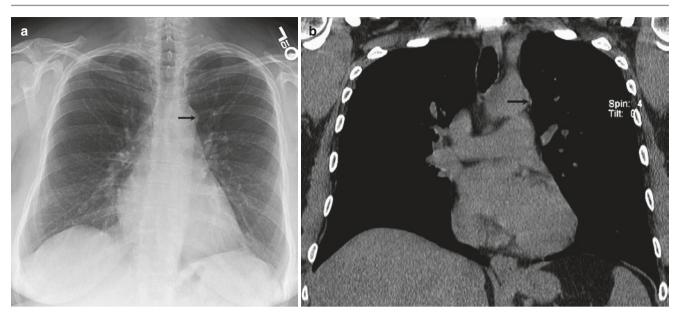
Aortic nipple. (a) Frontal chest radiograph shows a nipple-like projection (arrow) from aortic knob. (b) Coronal unenhanced CT reconstruction shows a superior intercostal vein (arrow) accounting for the "aortic nipple"
